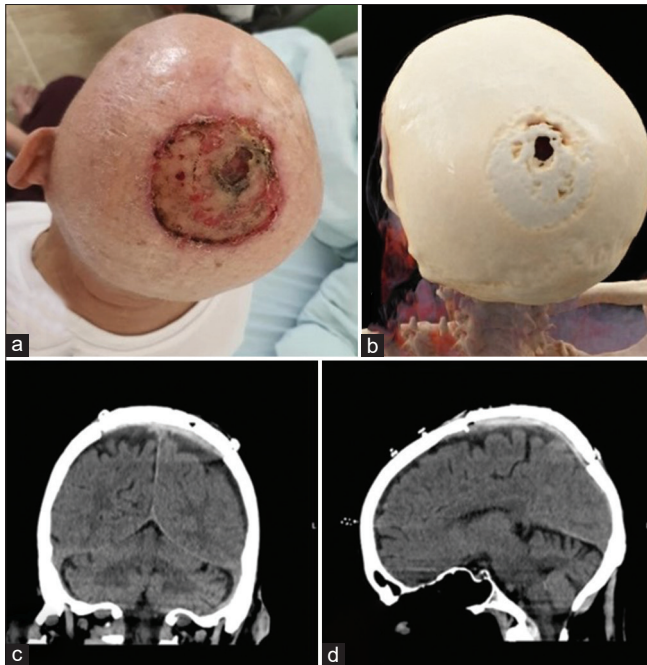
(a) Preoperative finding of planocellular carcinoma with continuous spread through the calvarial skin and parietal bone, (b) Cinematic rendering (CRT) of the head CT scan showing bone destruction, (c) coronal and (d) sagittal plane of the postoperative, non-enhanced CT scan one week after the surgery revealed an excellent implant fixation.
